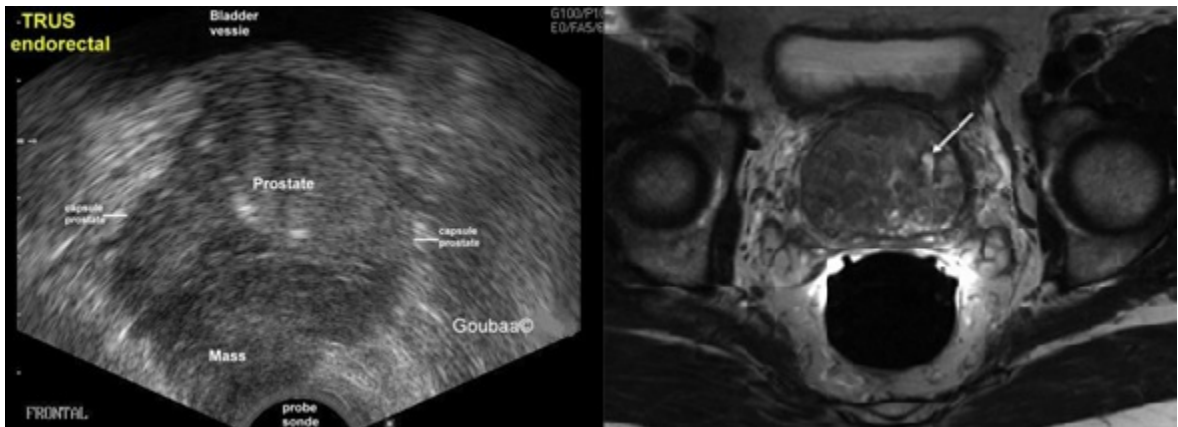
A comparison of TRUS and MRI images of the pelvic region. Left) TRUS ©Medical Echography, Right) MRI ©Indian Journal of Radiology and Imaging
